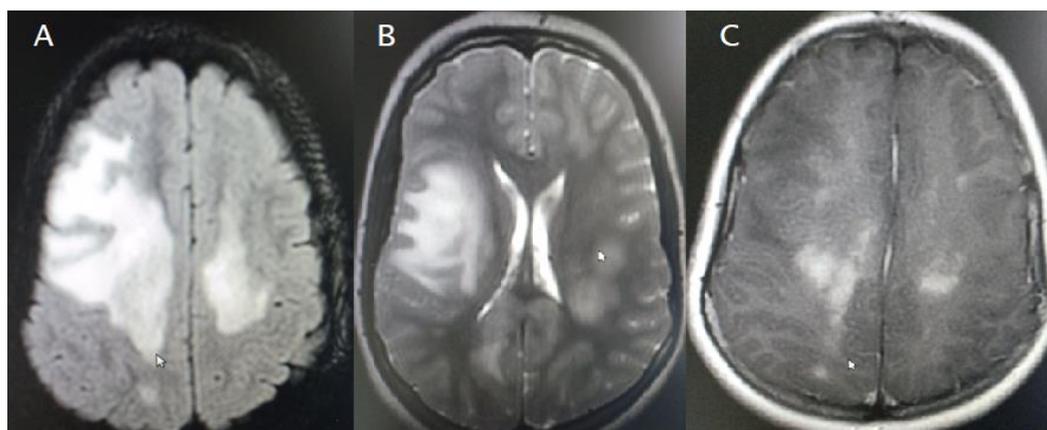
MRI brain demonstrating asymmetrical and bilateral hyperintense lesions within the deep white matter (A) Flair sequence, (B) T2-weighted sequence, (C) T1-weighted sequence.
